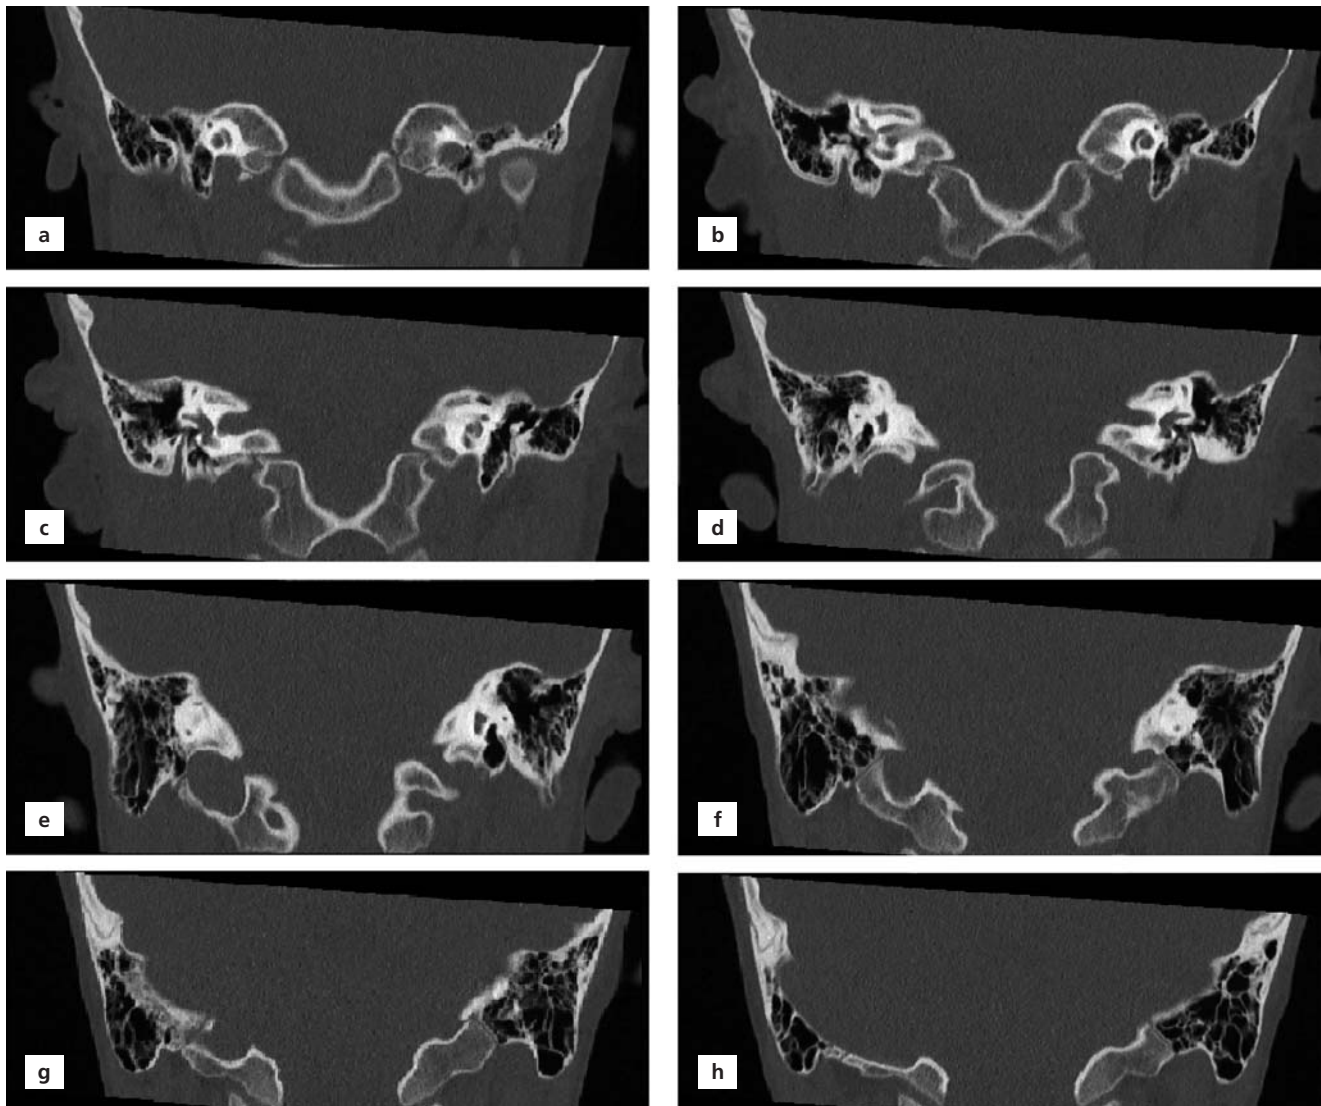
Coronal thin-section CT scans (a–h). The continuity of the atresia of the external acoustic meatus can be followed in sequential sections.
